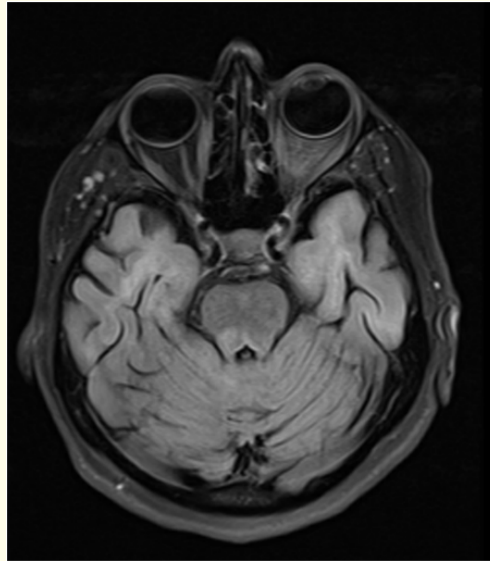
MRI T2 FLAIR sequence demonstrating an enhanced lesion at the right side of the pons explaining the presence of Bruns Nystagmus.
